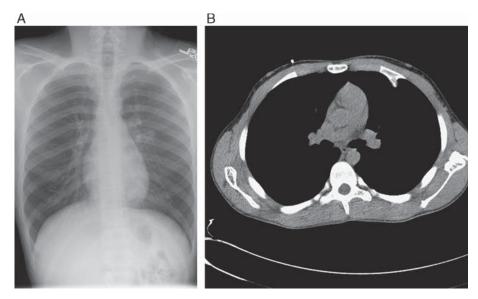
A, This chest x-ray shows no abnormalities in the patient who was treated for recurrent episodes of pneumothorax. B, This computed tomographic scan shows a pedunculated osteochondroma arising from the inner aspect of the left third rib as the cause of recurrent pneumothorax.
